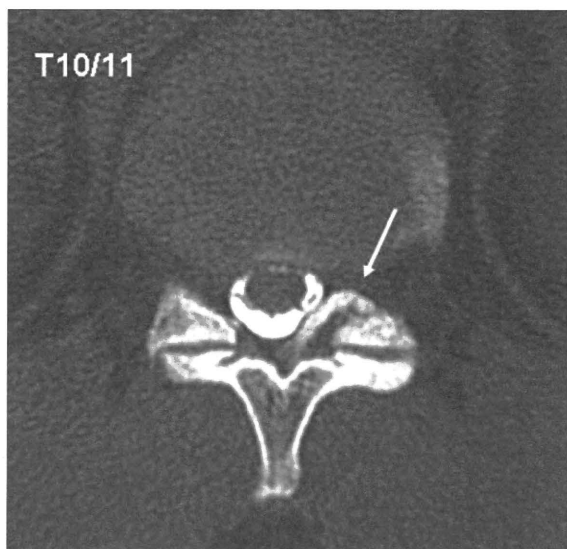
Computed tomography after myelography revealing the presence of OYL on the unilateral left side at T10-T11 (arrow) in patient 1.
